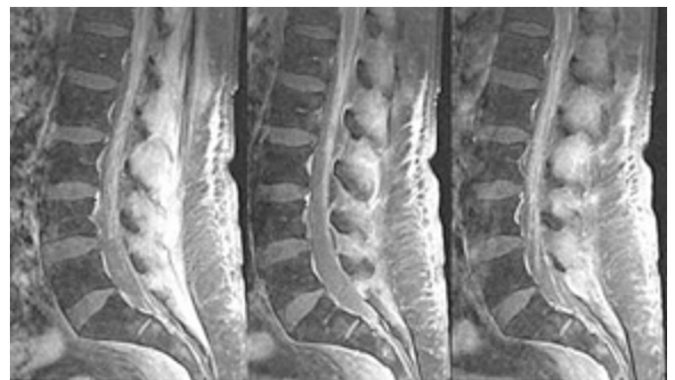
Parasagittal Gd-enhanced T1-weighted magnetic resonance images of the lumbosacral spinal cord obtained 13 days after inadvertent intrathecal daunomycin administration, showing thickening and abnormal enhancement of the conus medullaris and cauda equina.
